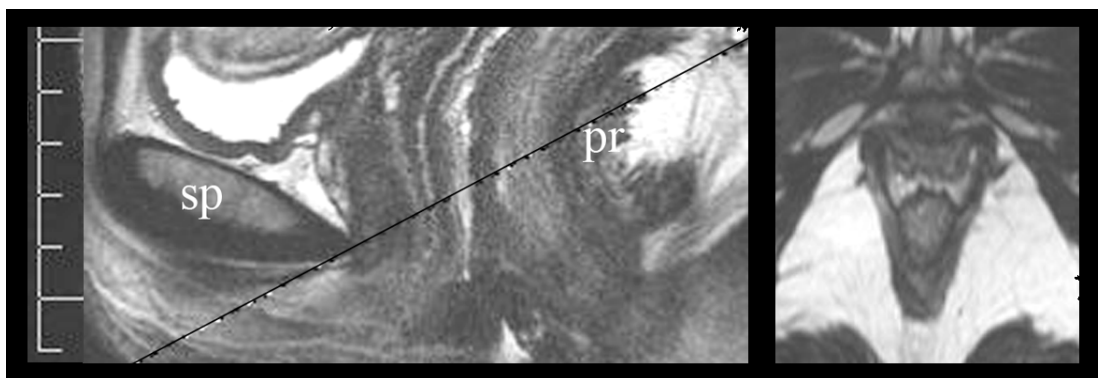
Identification of the hiatal plane on Magnetic resonance imaging: midsagittal plane on the left, oblique axial on the right.
